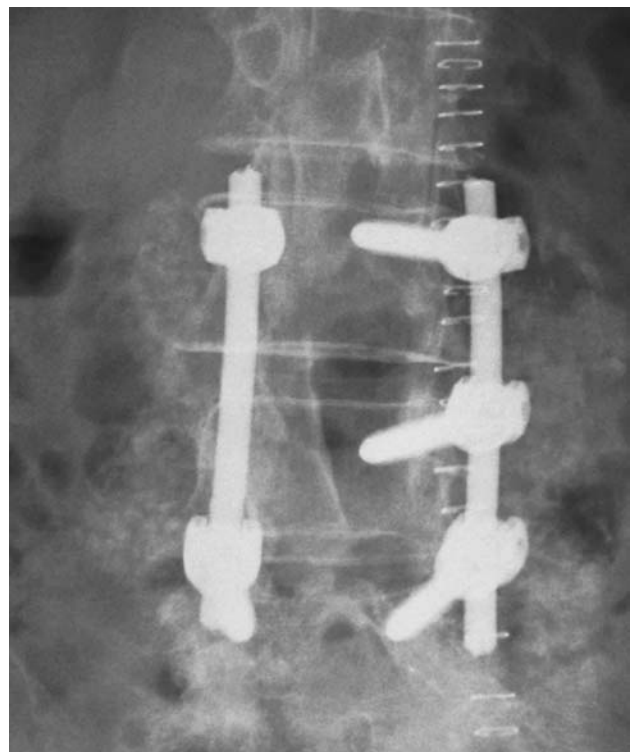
A radiograph showing an anteroposterior (AP) view of a two-level fusion following decompression taken immediately post-surgery. Grafting consisted of decompression material and DBM. The entire graft mass is not readily observed as the DBM is not radiopaque
